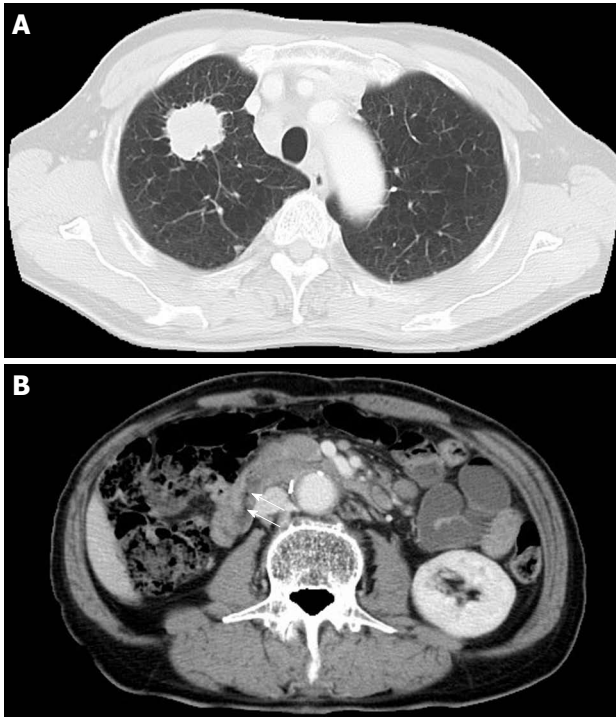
Chest computed tomography images of primary lung adenocarcinoma (A) and abdominal computed tomography images before gemcitabine (B). A: Chest computed tomography before chemotherapy revealed a tumor of 2.5 cm in diameter with spike-like projections; B: Walls of the duodenum become thickened at the second portion (arrows).
